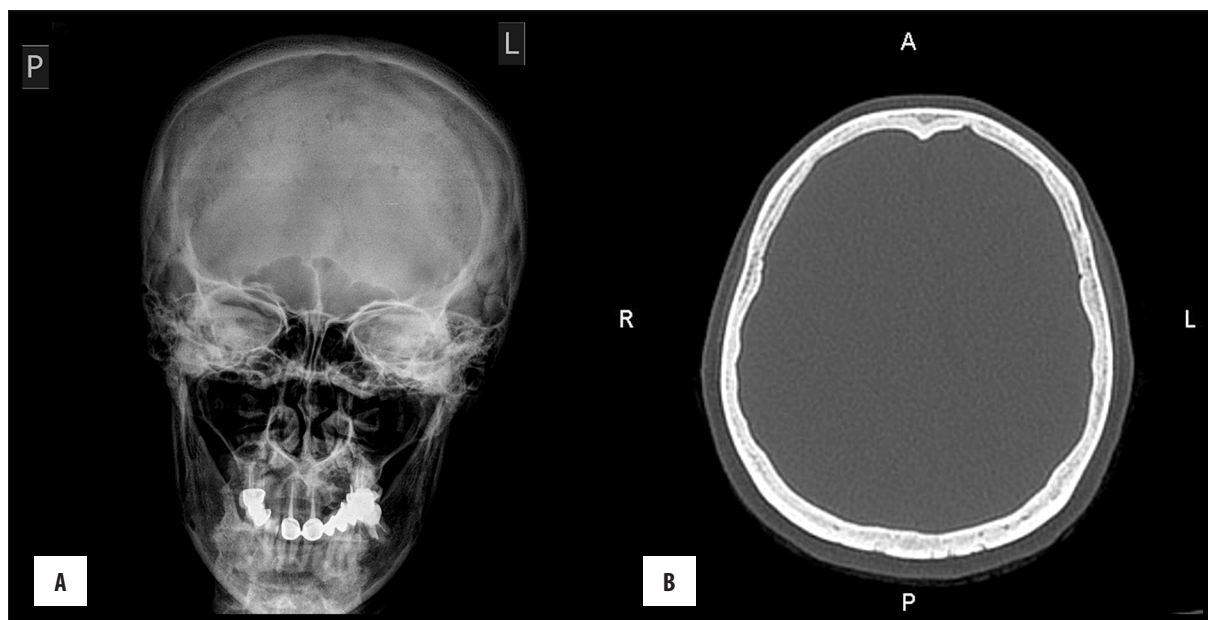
(A) X-ray and (B) CT axial image, suspicion of lytic lesions on skull radiograph that on CT turned out to be arachnoid granulations fovea.
